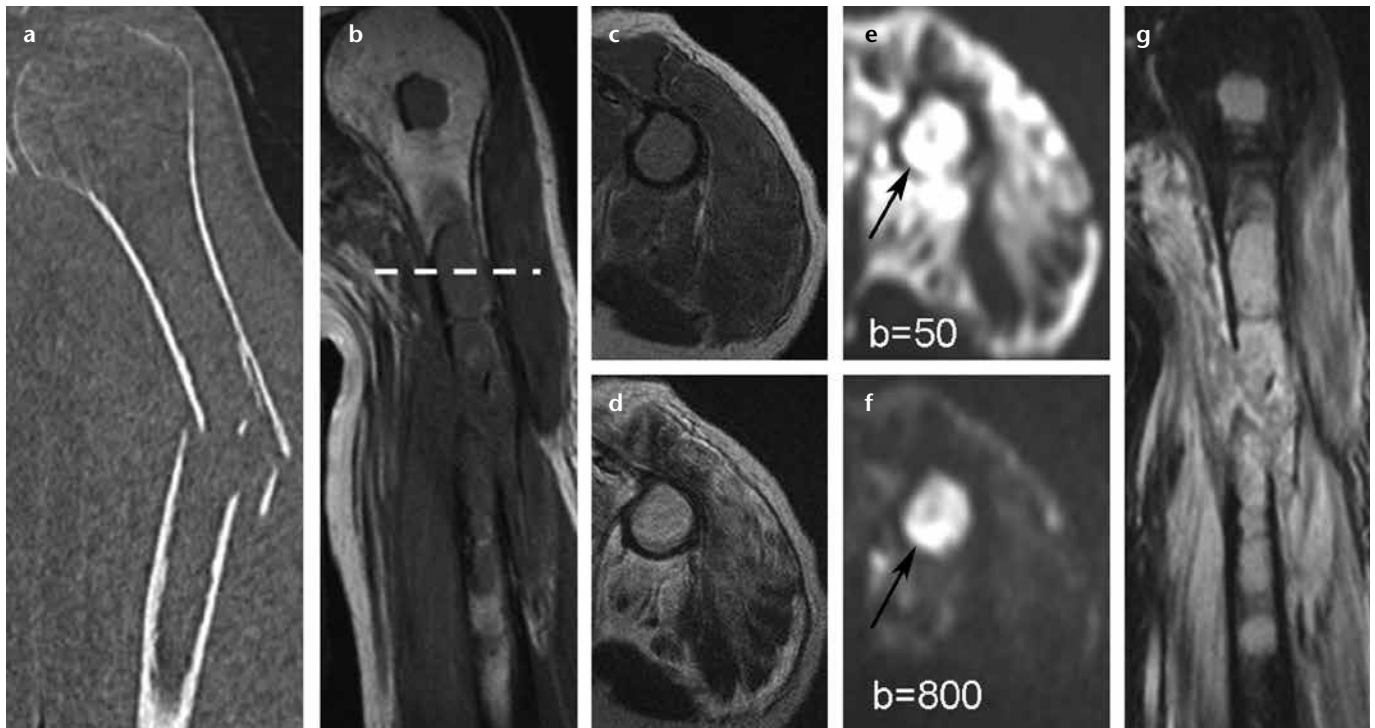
a–g. A 79-year-old male presented with left arm pain following a fall. Radiographs (not shown) and coronal-reformatted CT image (a) shows a humeral shaft fracture. A pathological fracture was suspected. The coronal T1-weighted image (b) shows abnormal hypointensity in the humeral bone marrow, extending to the humeral head. Axial T1-weighted (c) and T2-weighted (d) images at the level of the dotted line in (b) show hypointensity and intermediate signal intensity, respectively, of the humeral bone marrow. The extensive intramuscular and perimuscular hematoma resulting from the injury is seen as hyperintensity in both (c) and (d). On both low b (e) and high b (f) diffusion weighted images, the humeral bone marrow is hyperintense (arrows), with low ADC values (not shown). The lesion is hyperintense in the coronal STIR image (g), suggesting the loss of normal fatty marrow. A biopsy of the lesion at the fracture site yielded a diagnosis of multiple myeloma.
